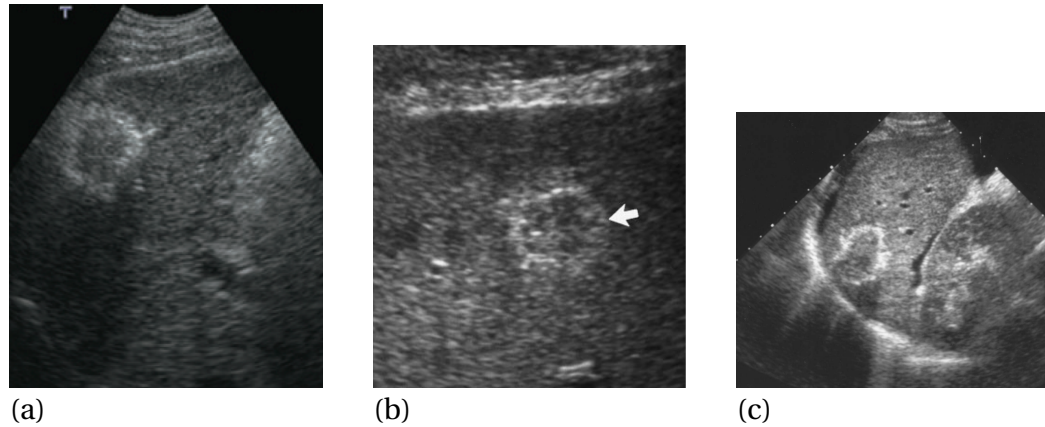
Three examples from the literature of hyperechoic rims observed in ultrasound images. Reproduced from: (a) Uehara *et al.*, *Hepatol Res* 39: 954-962; (b) Leifer *et al.*, *Radiology* 214: 167-172, arrow shows isoechoic lesion with a hyperechoic rim; (c) McGahan and Dodd III, *Am J Roentgenol* 176: 3-16
